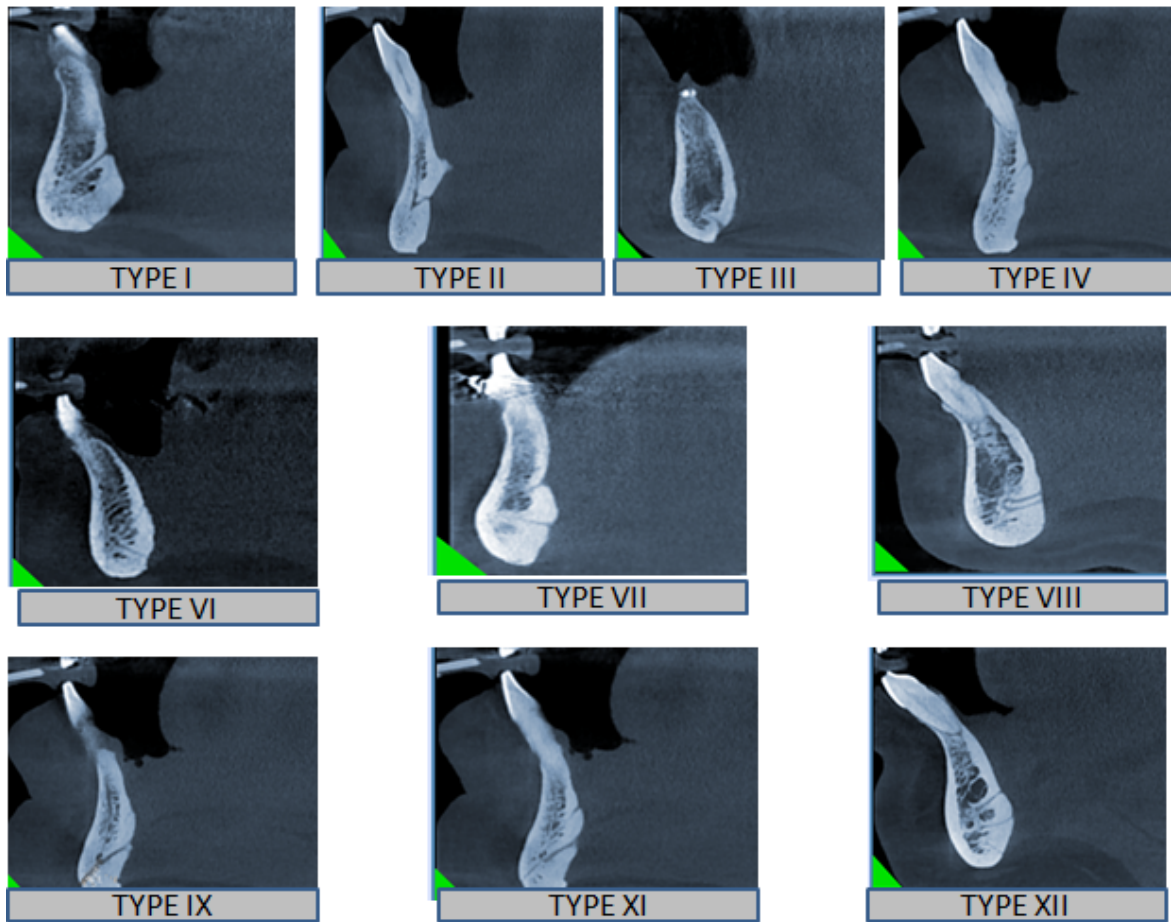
Radiographic types of lingual foramen recorded in study sample
